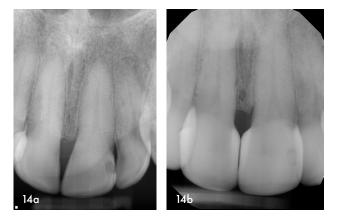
Preoperative (14a) and immediate postoperative (14b) radiographs are shown. Note the smooth transition of the tooth-restoration interface (TRI) and the aggressive change in emergence profile. One of the key elements of the method is the change in emergence profile begins subgingivally. That subgingival adaptation and aggressive emergence profile was difficult to achieve before the advent of a dedicated black triangle matrix.
